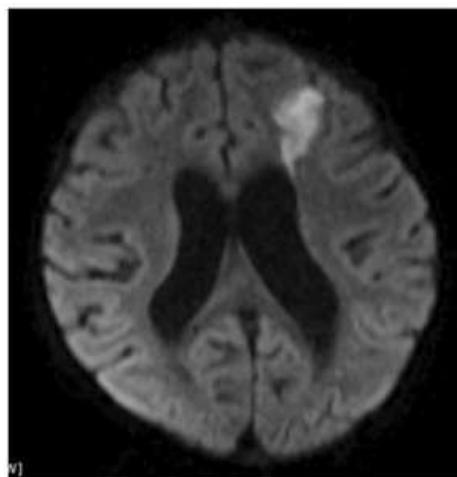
Axial T1WI (a) and T2WI (b) images showing areas of altered signal intensity in left watershed areas appearing hypointense on T1WI and hyperintense on T2WI images. These areas are showing restriction on DWI (c) with corresponding low ADC values (d). This was suggestive of acute infarct in left anterior and posterior watershed areas suggestive of watershed pattern.
